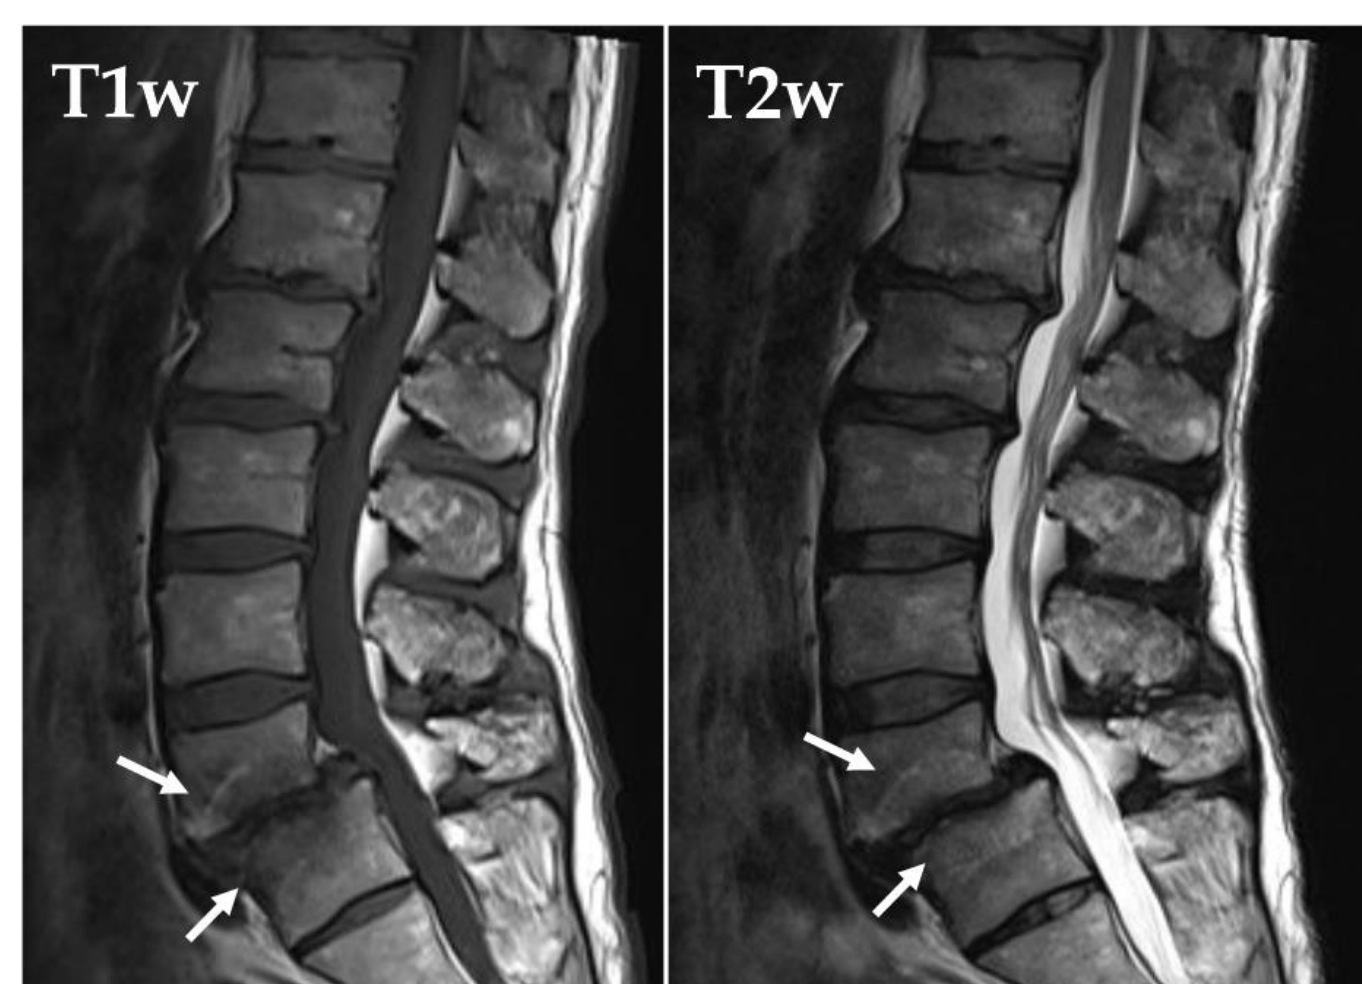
Modic changes on T1-weighted and T2-weighted magnet resonance images (MRI). White arrow indicate Modic lesion.
